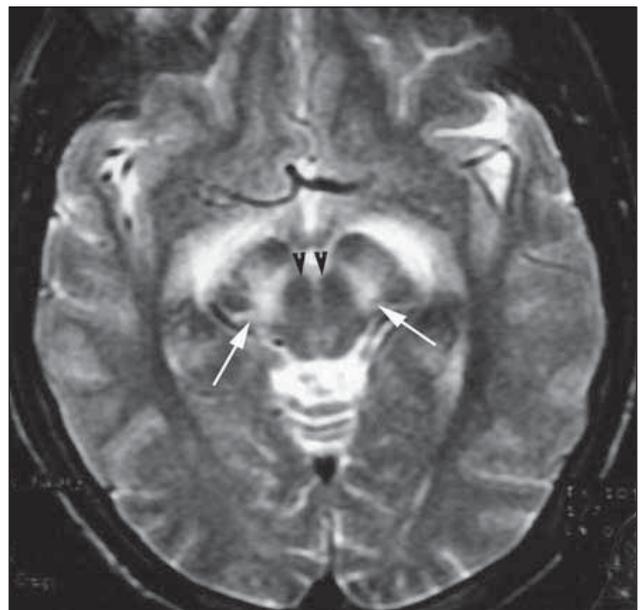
Mid brain lesions: involvement of cerebral peduncles and sparing of red nuclei. Axial T2 weighted SE MR image shows bilateral hyperintense lesions of cerebral peduncles and adjacent regions (arrows).
